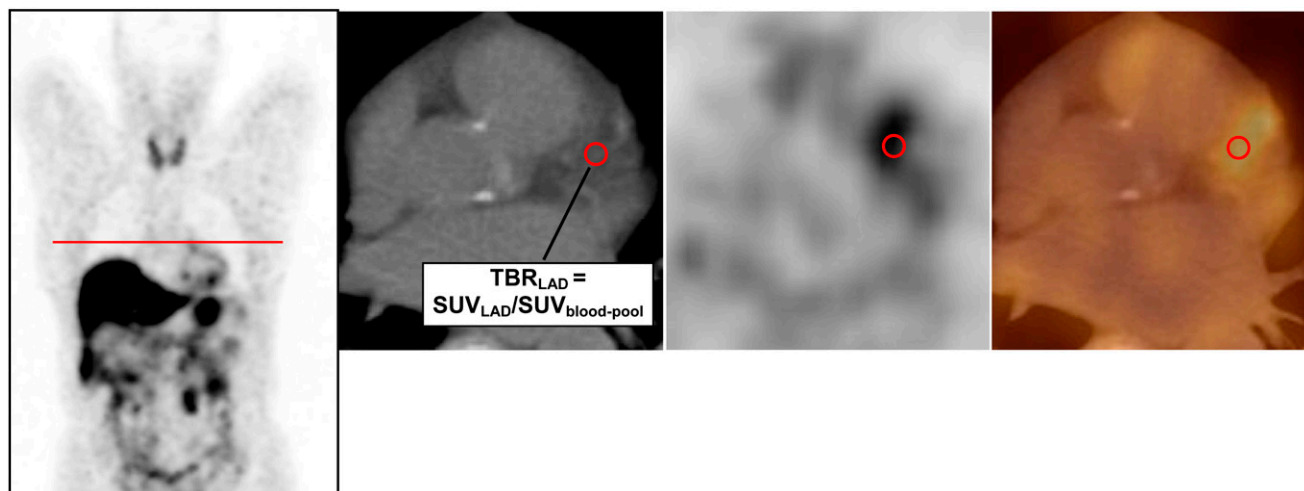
PET/CT image analysis. Example of SUV measurement in LAD. PET/CT images of 64-y-old woman with history of smoking (40 pack-years), diabetes, and hypercholesterolemia. From left to right: first panel shows coronal slice of PET scan. Red line indicates same axial slice as that presented in other 3 images. Second panel shows axial CT image of coronary artery, which was used to localize LAD. Red circle in panels 2, 3, and 4 indicates ROI, placed in LAD. Third panel shows axial PET slice, and fourth panel shows fused CT and PET image. SUV was measured on fused PET/CT images along course of vessel. Maximum SUV in this patient was 0.9, and mean venous SUV in upper and lower vena cava was 0.5, resulting in target-to-background ratio (TBR) of 1.8.
